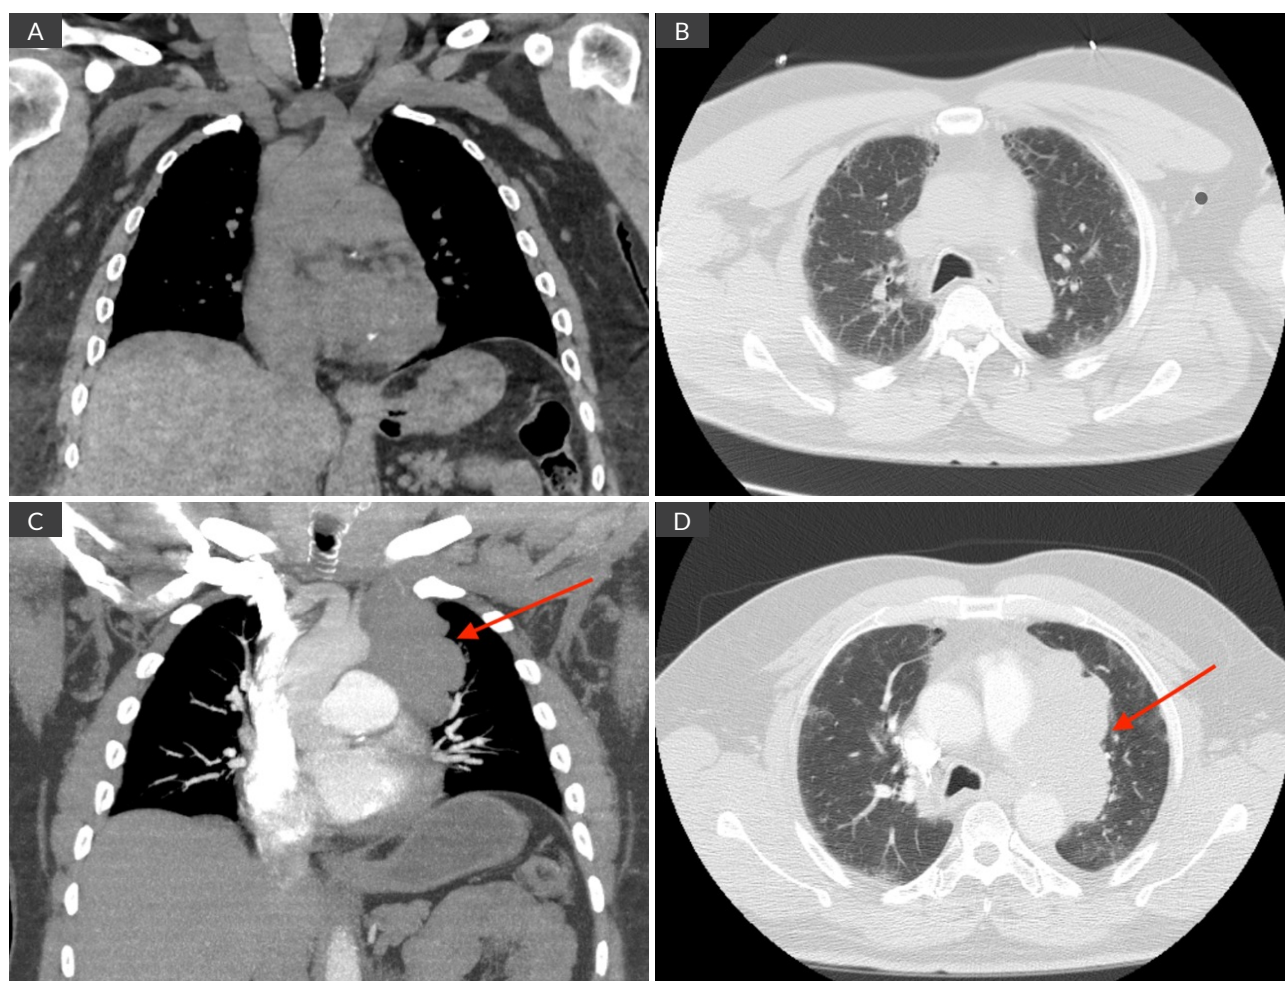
A) Computed tomography scan of the chest coronal cut showing no apparent mass; B) Computed tomography scan of the chest axial cut showing no apparent mass; C) Computed tomography scan of the chest coronal cut 6 months later showing large lobulated mass (red arrow); D) Computed tomography scan of the chest axial cut 6 months later showing large lobulated mass (red arrow).
